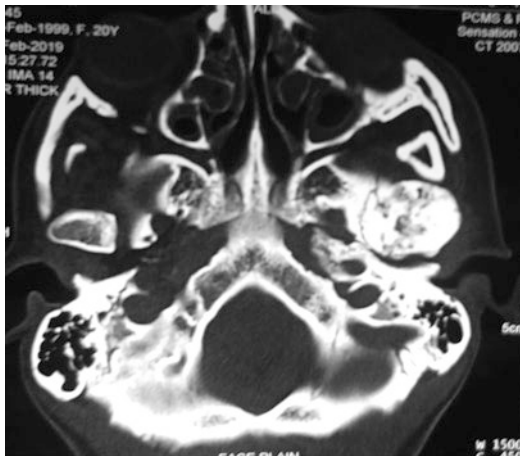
Axial section of a computed tomography (CT) scan depicting extensive unilateral ankylosis of the left temporomandibular joint
